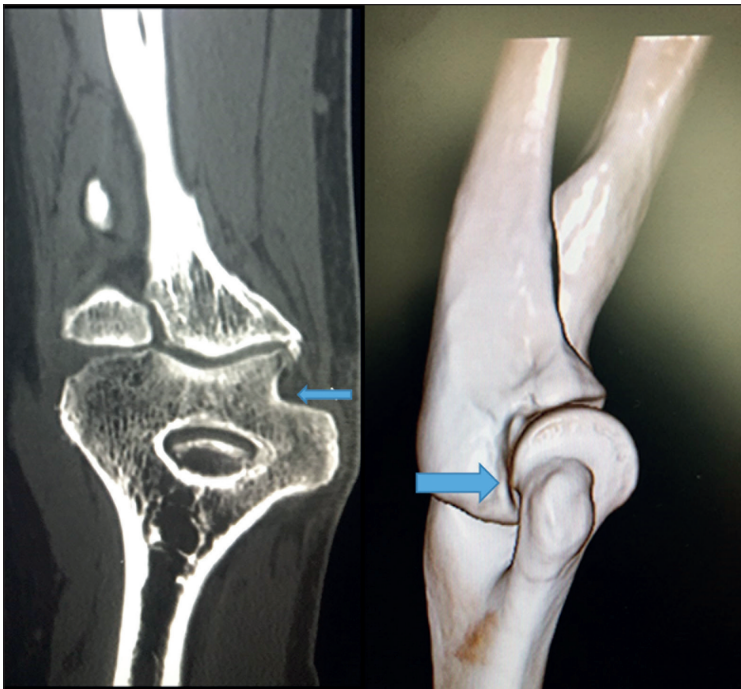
3D CT image of the cubital tunnel. Obstruction of the cubital tunnel with osteophytes.
